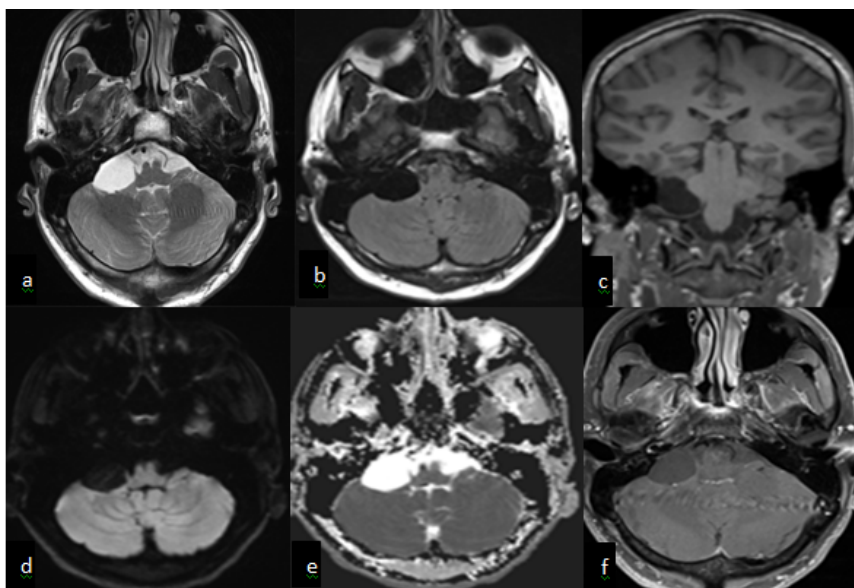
Arachnoid cyst. (a) Axial T2-weighted, (b) axial FLAIR imaging images and (c) coronal T1-weighted showing a well-defined cerebrospinal fluid signal intensity lesion at right cerebellopontine angle, (d) Axial diffusion-weighted image and the (e) corresponding apparent diffusion coefficient (ADC) map show no restricted diffusion. (f) On post contrast T1-weighted sequences no contrast enhancement
